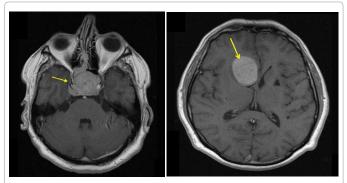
Magnetic Resonance Imagery showing a pituitary adenoma of 7 by 4 cm in an adult male; transverse plane at different levels (yellow arrow).
